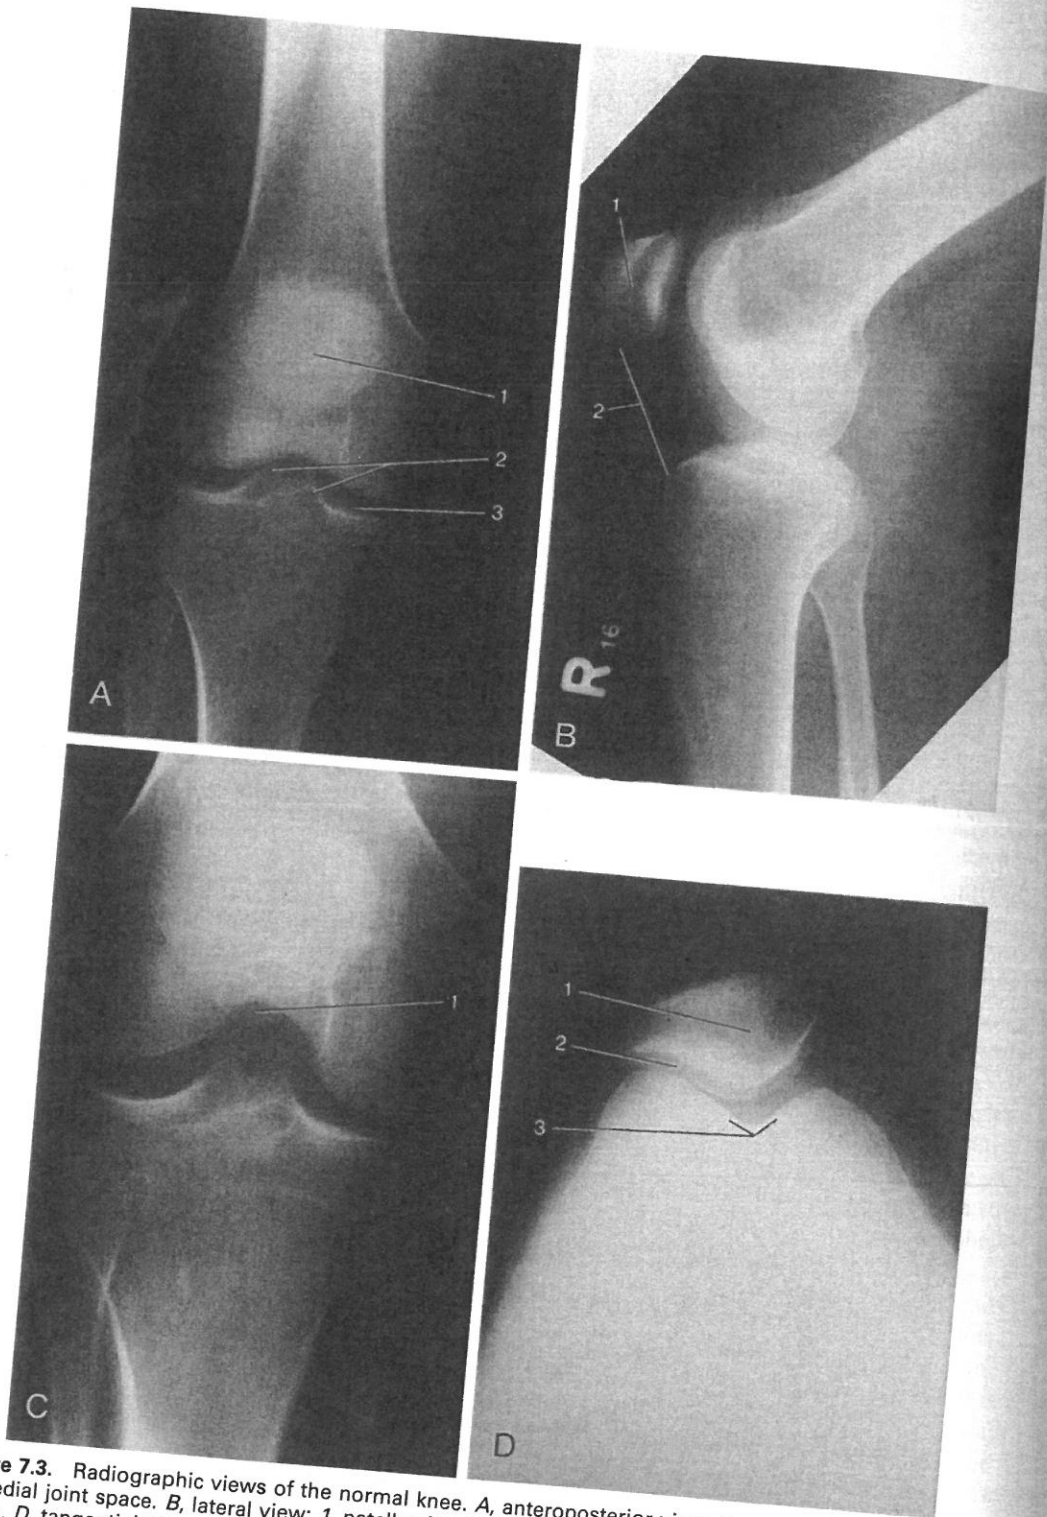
Radiographic views of the normal knee. *A*, anteroposterior view; 1, patella; 2, tibial spines; 3, medial joint space. *B*, lateral view; 1, patella; 2, patellar ligament. *C*, tunnel view; 1, intercondylar notch. *D*, tangential view; 1, patella; 2, lateral patellar facet; 3, trochlear groove.
